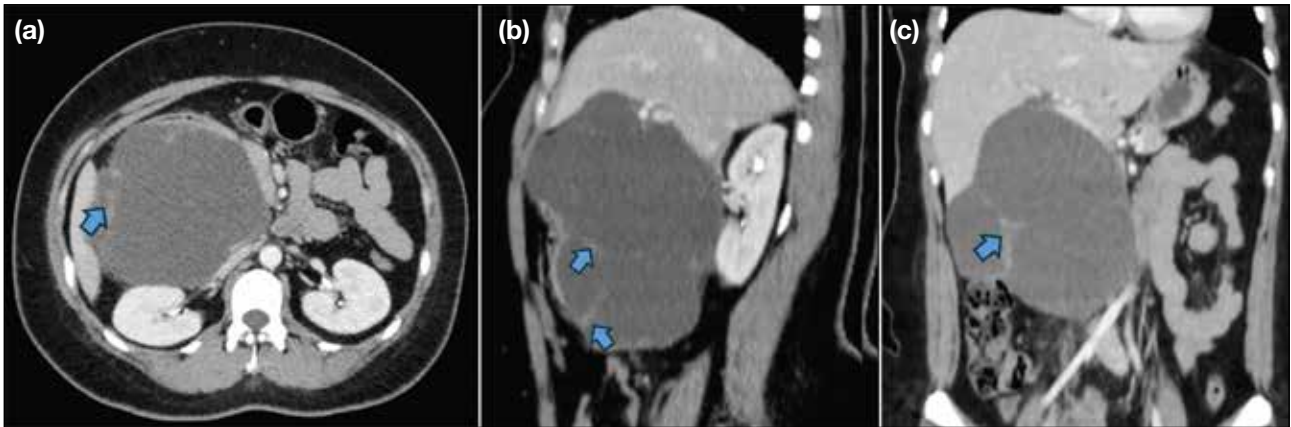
Contrast-enhanced computed tomography scan of the whole abdomen of the patient with a large, lobulated cystic mass lesion with incomplete non-enhancing septations (arrows) seen in the right subhepatic space exerting mass effect on the adjacent structures. (a) Axial view. (b) Sagittal view. (c) Coronal view.
